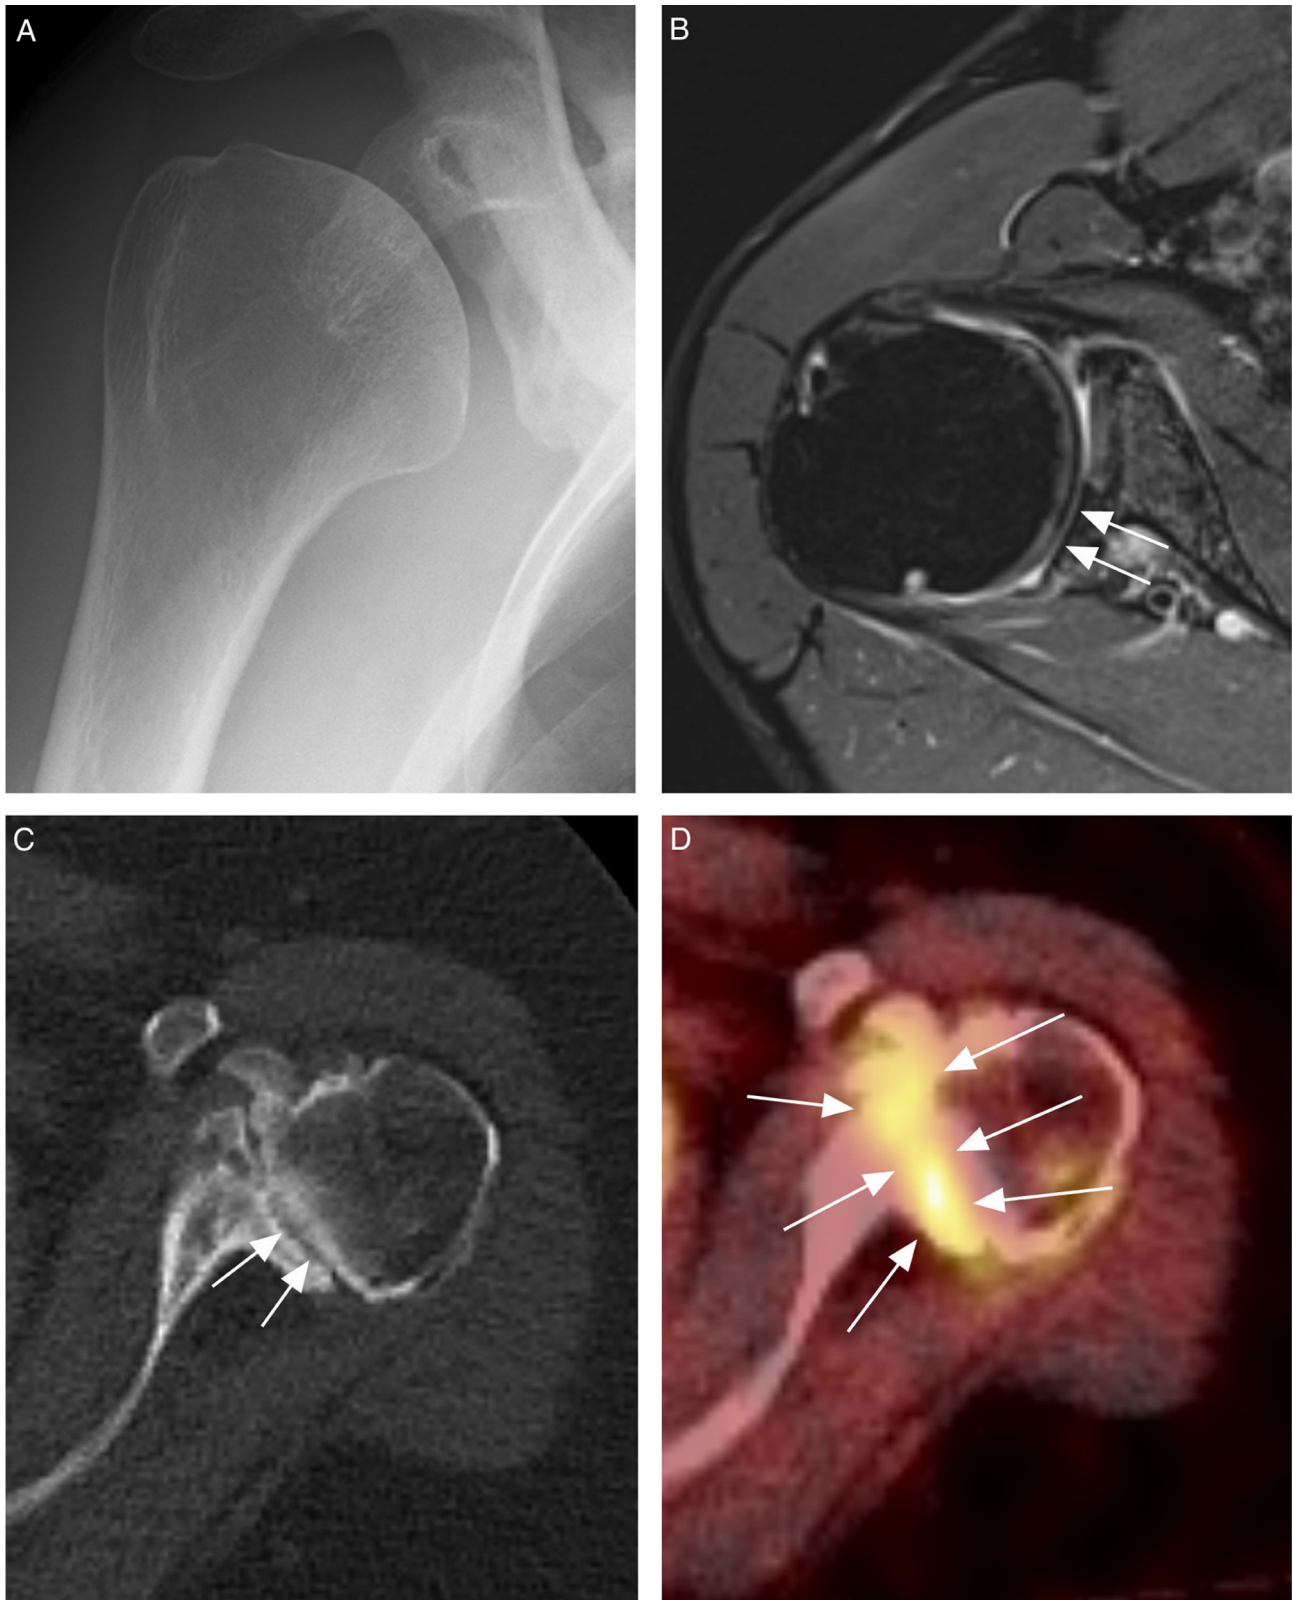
Advanced OA due to anatomical variants. A. Anterior–posterior radiograph of gleno-humeral joint shows marked dysplasia of glenoid without evident signs of OA. B. Corresponding axial fat suppressed proton density-weighted MR image depicts marked cartilage loss at posterior aspect of glenoid (arrows) representing early signs of OA not revealed by radiography. C. Axial CT image of a different patient with glenoid dysplasia shows severe narrowing of joint space (arrows) and periarticular sclerosis. Note deformity of humeral head and glenoid. D. Corresponding axial fluorodeoxyglucose - positron emission tomography (FDG-PET) image depicts markedly increased glucose uptake within the joint space reflecting synovitis and explaining incident pain in this patient (arrows).
